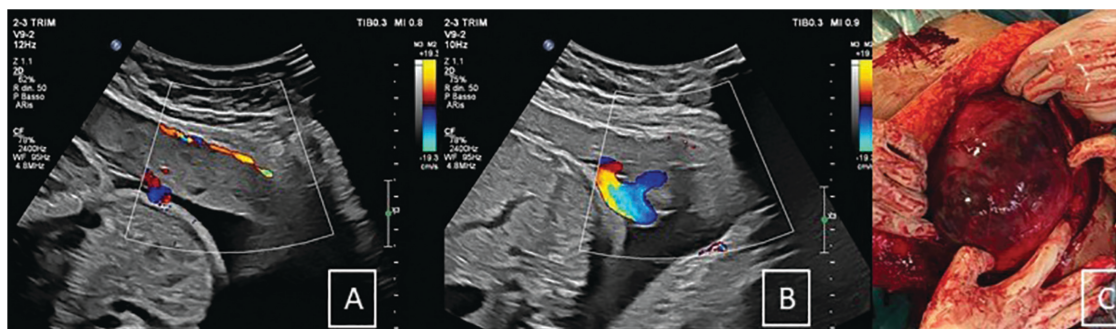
(A, B) Ultrasound images of placenta at third trimester scan. (C) Absence of a part of anterior uterine wall due to misdiagnosed placenta accreta.
